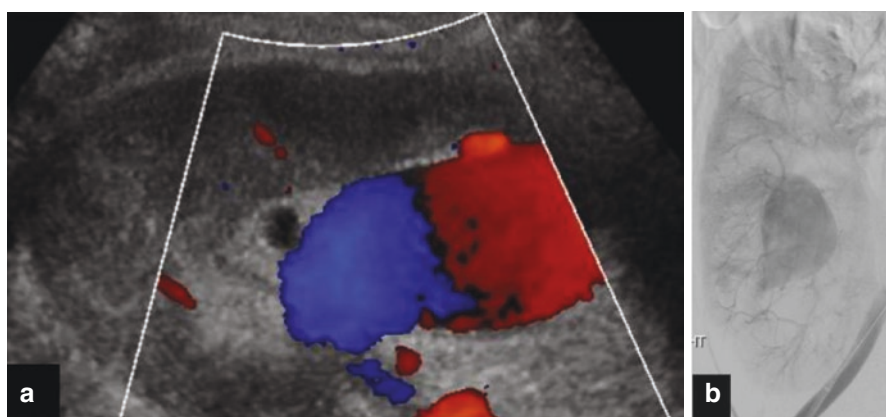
(a) Color Doppler ultrasound demonstrating classic to-and-fro appearance of a large intrarenal pseudoaneurysm. (b) Corresponding pseudoaneurysm on spot image from an external iliac digital subtraction angiogram
